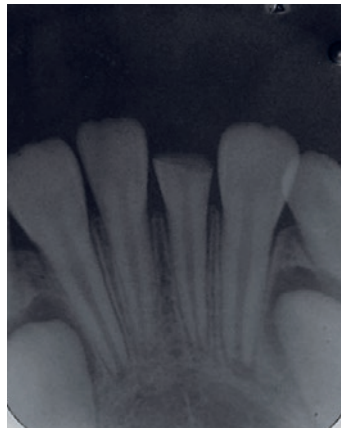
First radiograph.
